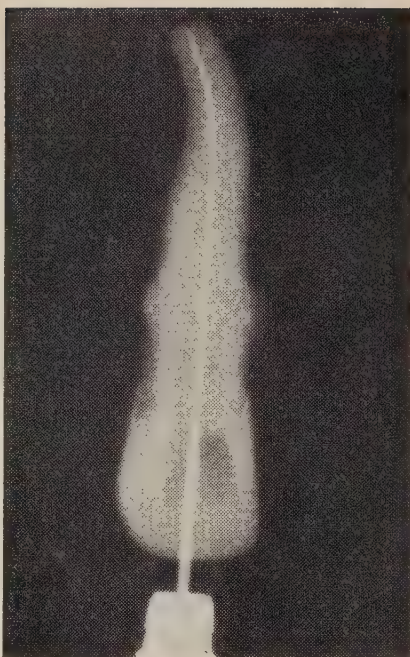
Radiograph showing curved apical portion of root canal with instrument in place. The instrument was bent as shown on the right.
